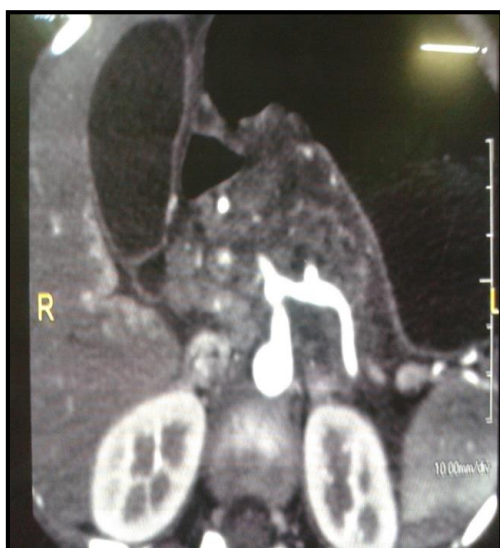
CT angiography: s/o pseudoaneurysm in splenic artery.
